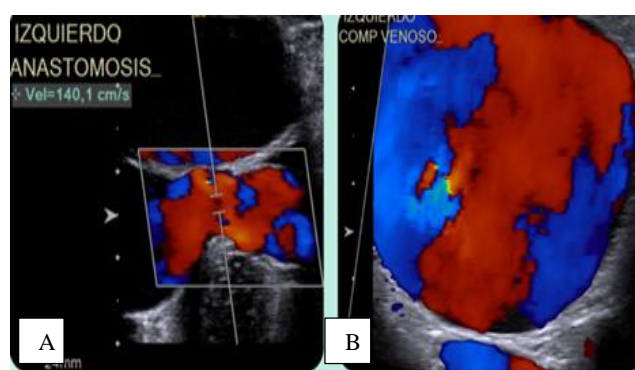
(A and B): Doppler ultrasound showing AVF between the humeral artery and basilic vein.
